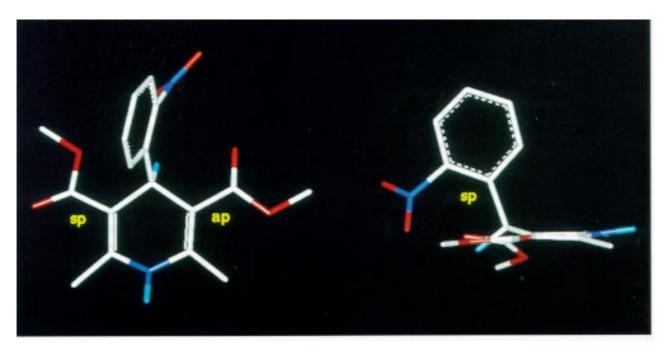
X-ray structure of nifedipine [20], coloured by atom type: carbons white, oxygens red, nitrogens blue and hydrogens cyan. For clarity, only the hydrogens in positions 1 and 4 are shown (sp, synperiplanar; ap, antiperiplanar).
